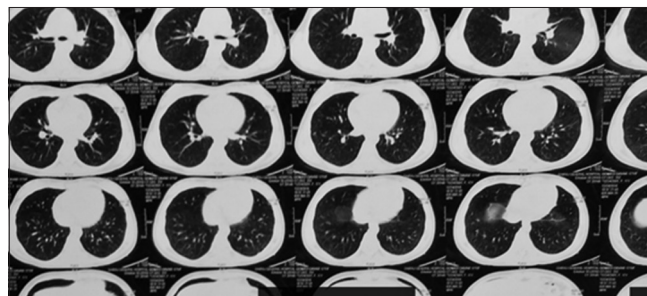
Contrast-enhanced computed tomography of the thorax suggestive of bilateral nodular opacities with a tree in bud appearance
